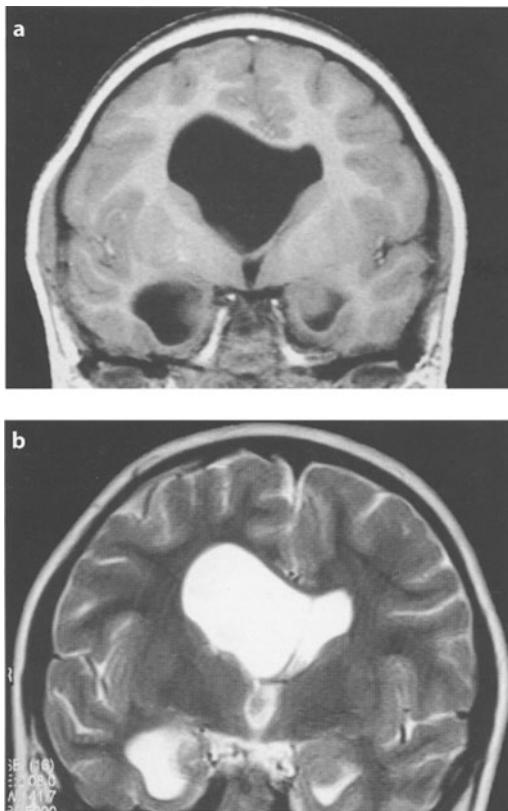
a, b. Thirteen-year-old girl, born at term, no relevant medical history. Unilateral hydrocephalus due to membranous stenosis of the right foramen of Monro. a Preoperative MRI. b After endoscopic fenestration of the membrane occluding the foramen of Monro, flow artifact is visible within the third ventricle
